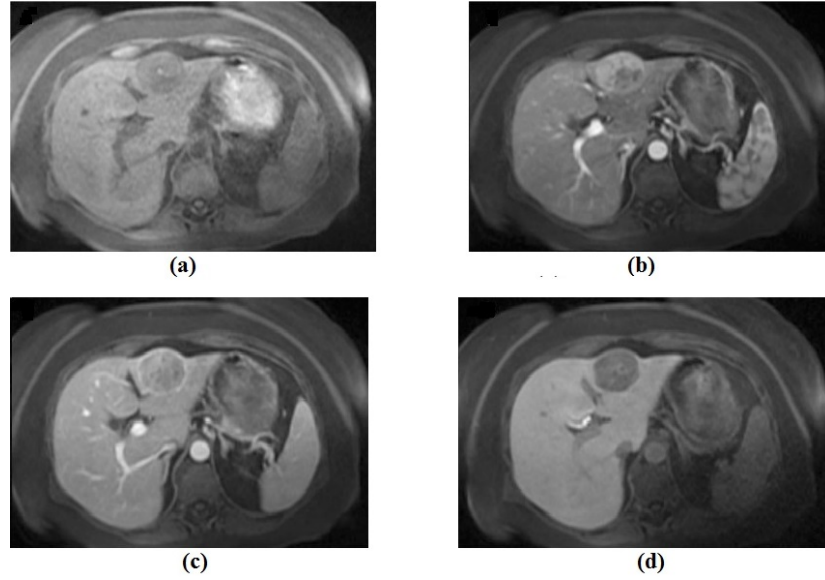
Example of MRI image Axial fat-suppressed T1-weighted with different phases. (a) unenhanced phase. (b) arterial phase. (c) portal phase. (d) late phase at 20-min.
